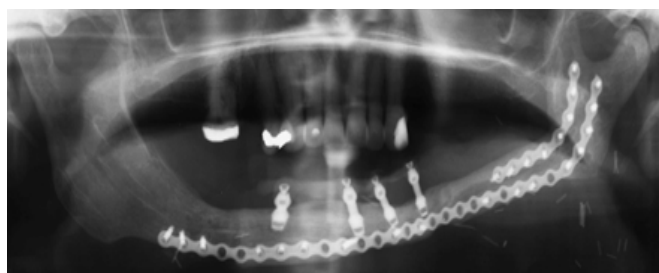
Panoramic and lateral cephalometric radiograph after insertion of four 4.0x5.0 mm calcium phosphate coated extra SHORT® Bicon Implants into the fibula graft.
